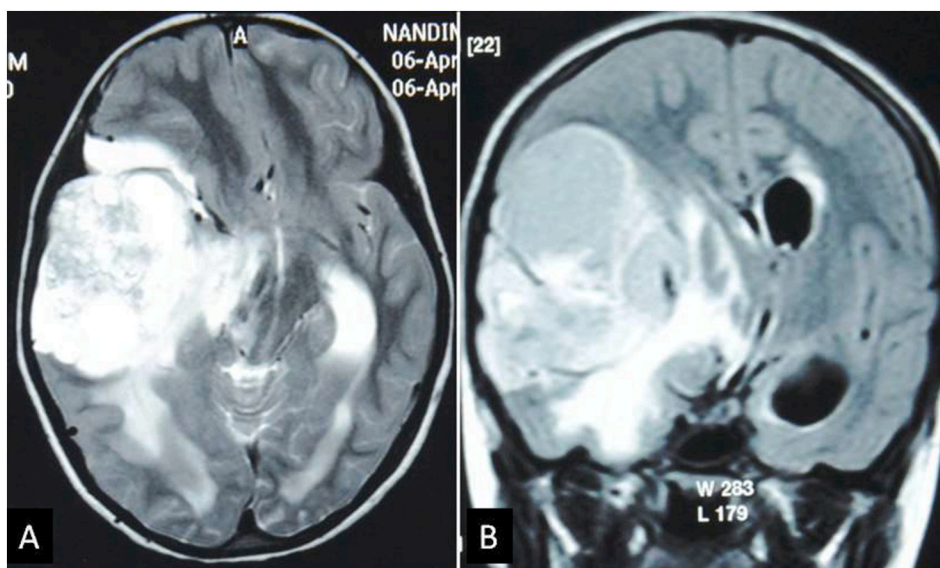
(A and B) Magnetic resonance imaging showing a large heterogeneously enhancing mass involving parietal and temporal lobes.
